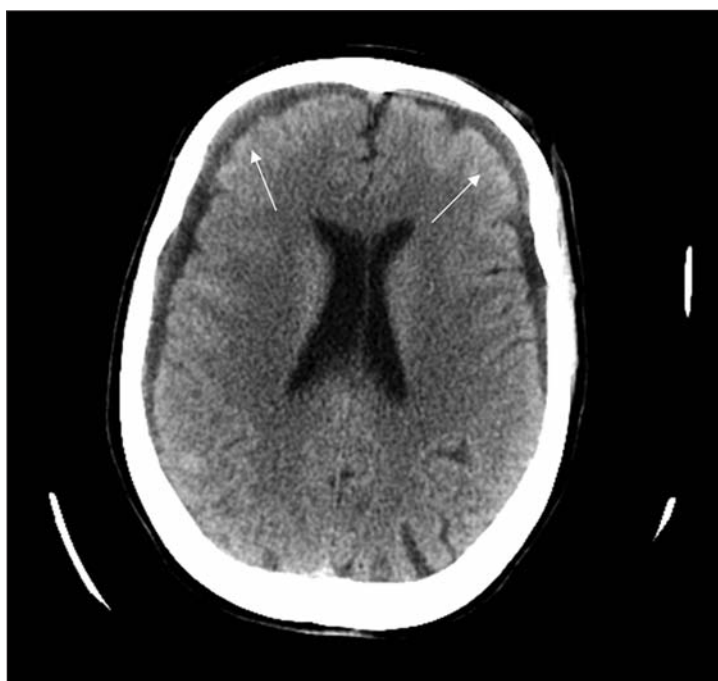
24 Hours Post Admission uninfused CT Head. Axial image of uninfused CT-head 24 hours post injury. Image displays bilateral hypodense subdural collections with loss of cortical volume, consistent with extra-axial collections that developed in response to significant acute brain volume loss.
